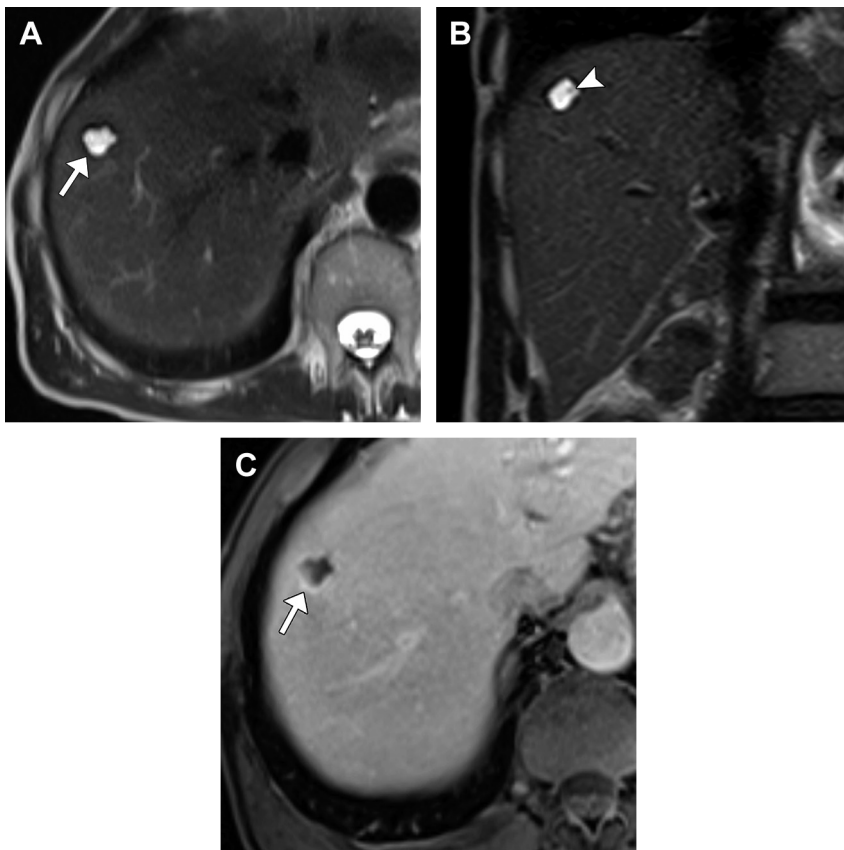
Bile duct hamartoma. (A) Small well-defined T2 hyperintense lesion (arrow) with lobulated margins has a suggestion of a few thin internal septations. (B) Coronal T2-weighted image demonstrates a tiny mural nodule owing to conjunctive septae (arrowhead), a finding proposed to increase diagnostic specificity of BDH. (C) Post-contrast image shows a characteristic thin rim of enhancement (arrow).
